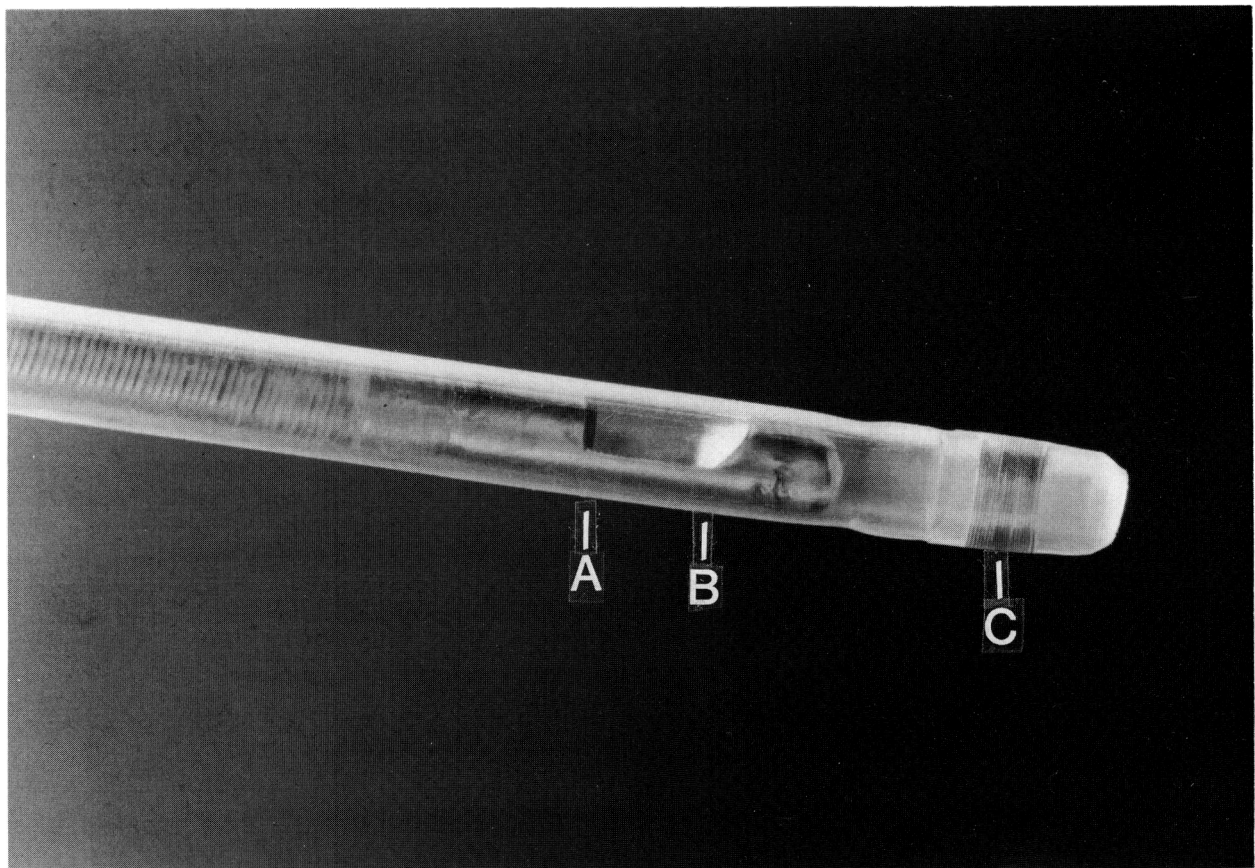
Intravascular ultrasound imaging subassembly inserted inside the 1.6-mm diameter plastic sheath. The 7-mm rigid end of the ultrasound subassembly includes the 20-MHz ultrasound transducer (A) and the reflective mirror (B) that deflects the ultrasound beam perpendicular to the long axis of the catheter. Distal end of the plastic sheath has a radiopaque marker (C).
